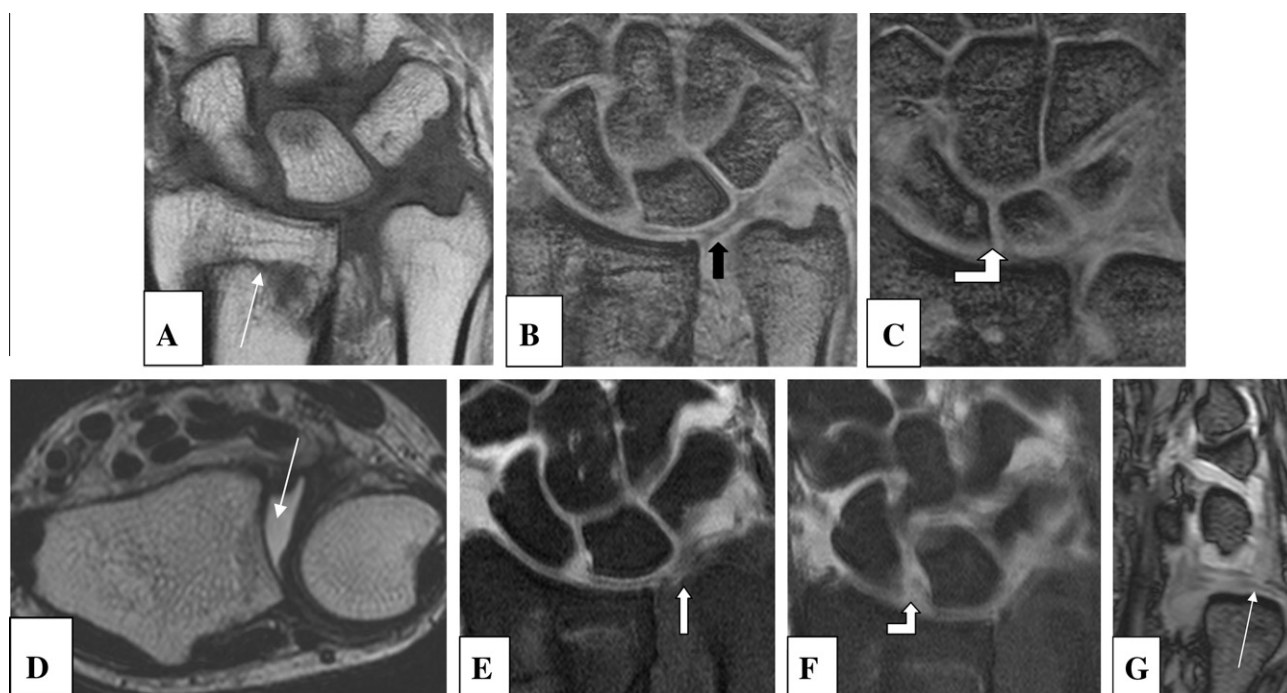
Male patient with pain at the dorsum of the left wrist after direct trauma underwent conventional MRI. Coronal T1 WI (A) revealed: malunited fractured distal radius (long arrow). Coronal T2 3D FFE WIS (B & C) shows altered signal of the central part of the TFC limited to its distal articular surface (black arrow) suggesting partial tear, and torn SL (scapholunate) ligament (curved white arrow). Axial T2 WIS (D) shows subluxation of the DRUJ, with moderate effusion noted (arrow). Intra articular injection was done into the mid carpal compartment, with free leakage of contrast into the radio-carpal joint space through the scapholunate interval, followed by MRA. Coronal T1 fat suppressed MR arthrographic images (E & F) show partial central tear of the TFC (arrow) class I–A, as well as tear of the SL ligament (curved arrow). Sagittal T1 3D FFE MR arthrographic image (G) shows partial tear of the TFC (arrow).
